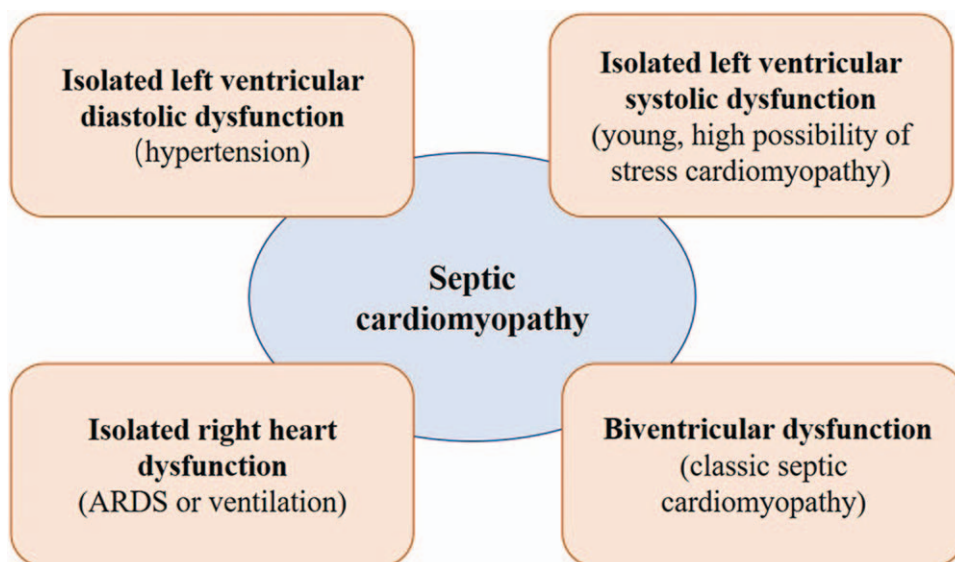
Four types of septic cardiomyopathy as shown by CUS. ARDS: Acute respiratory distress syndrome; CUS: Critical ultrasonography.
